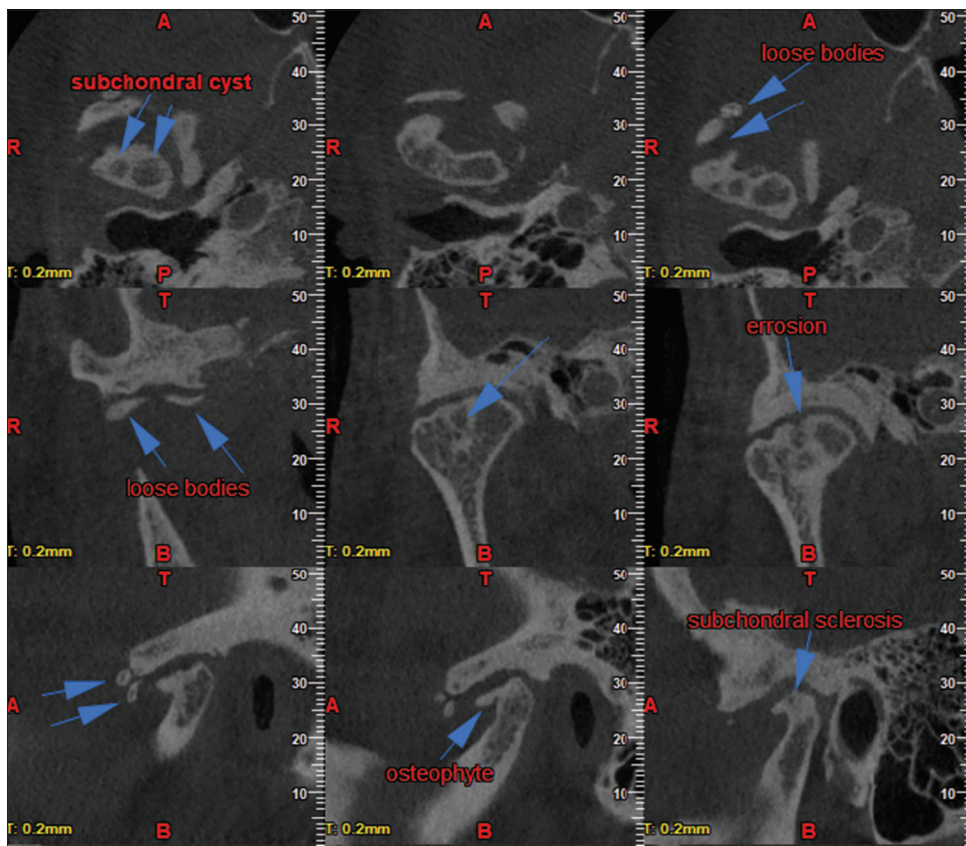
Cone-beam computed tomographic images. Sagittal, coronal, and axial view showing subchondral cyst, sclerosis, osteophytes, erosion, and loose bodies (blue arrows)
